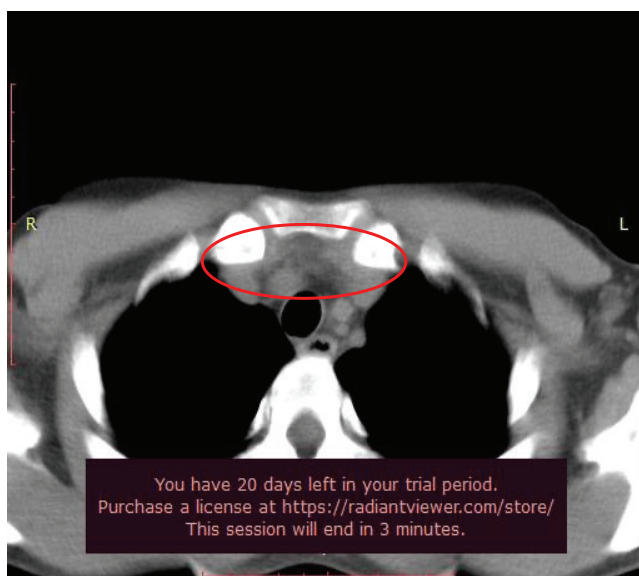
CT scan image of thymus hyperplasia
